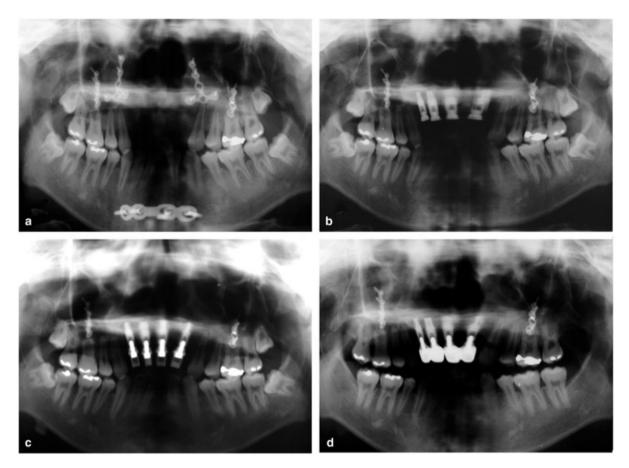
Panoramic radiographs at different stages of rehabilitation. (a) Four months after open reduction for maxillo-mandibular fractures, bone plates were retained at both jaws. Four anterior teeth in the maxilla were missing. (b) A vague shadow at the symphysis of the mandible represents the donor site of bone graft. The implant is obviously located far above the cervical line of the adjacent teeth. (c) The prosthetic cylinders on the implants show a vertical space longer than needed for the clinical crowns. (d) The implants are repositioned more occlusally when comparing the preoperative level of both apex and top of each implant with postoperative level.
